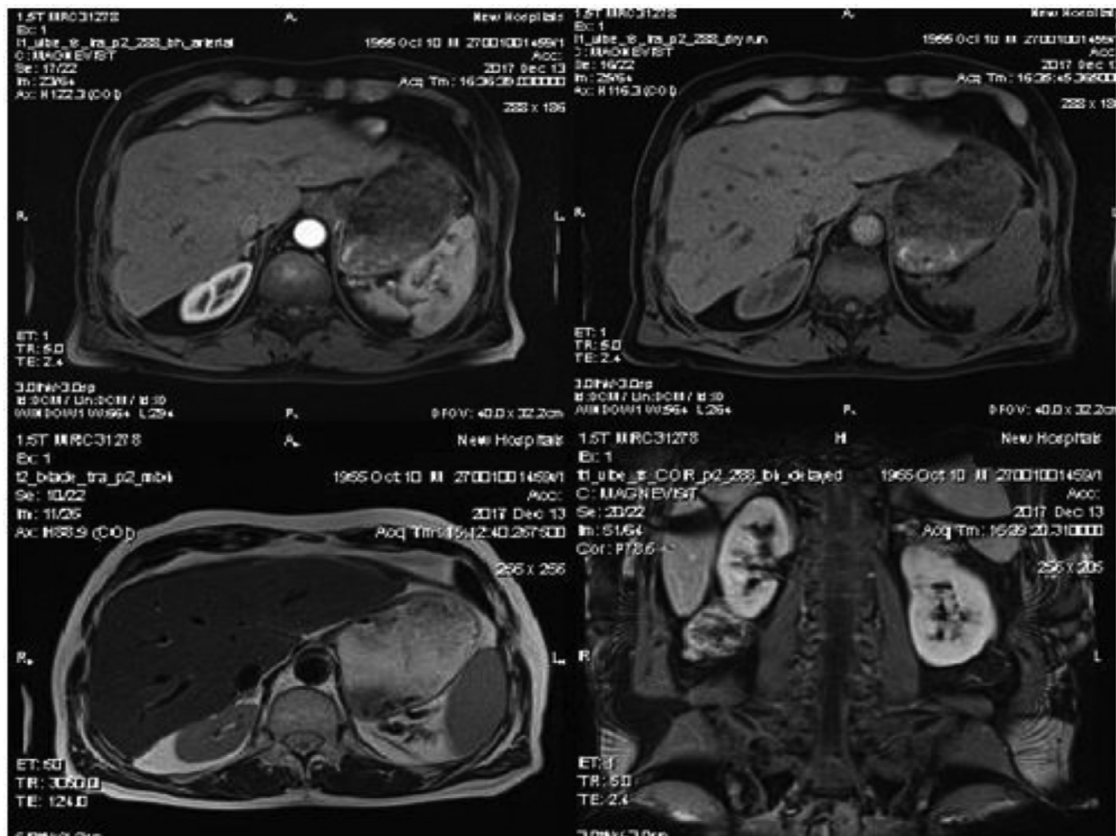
Follow-up MRI after TAE (5 years after treatment). No recurrence of liver tumor.
